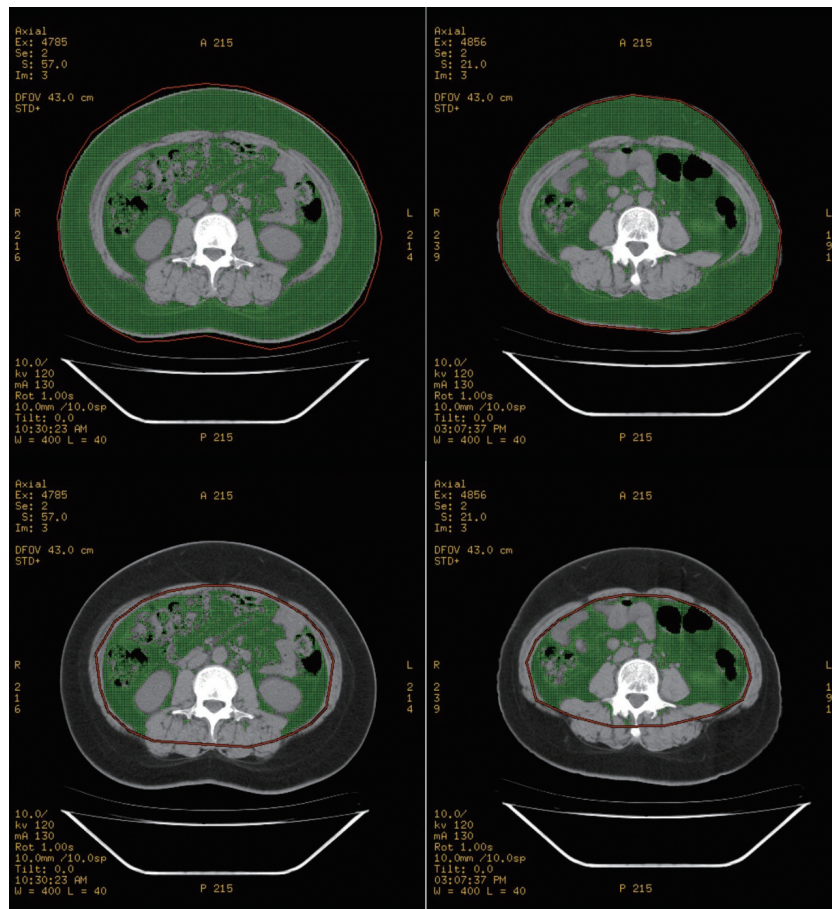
Abdominal CT images before and after EA treatment
